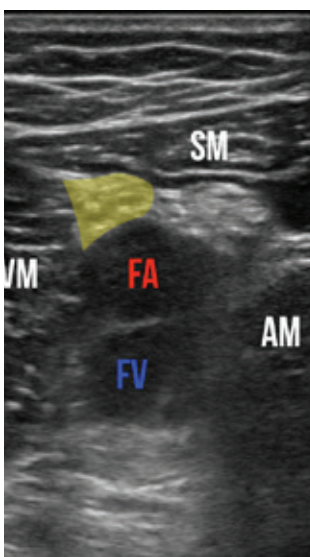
Sonographic view of the adductor canal. The saphenous nerve is highlighted.
